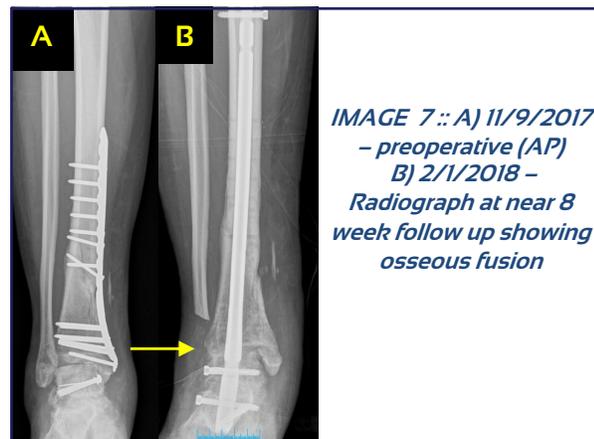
A) 11/9/2017 – preoperative (AP) B) 2/1/2018 – Radiograph at near 8 week follow up showing osseous fusion
